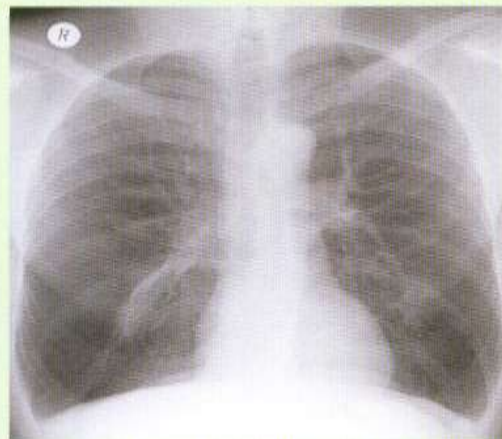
Chest X-rays in COPD
